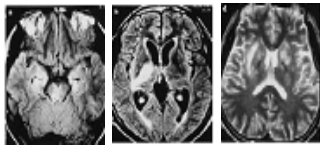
Axial T2-weighted images in NBD patients showing involvement of midbrain, internal capsule, thalamus, and basal ganglia.
